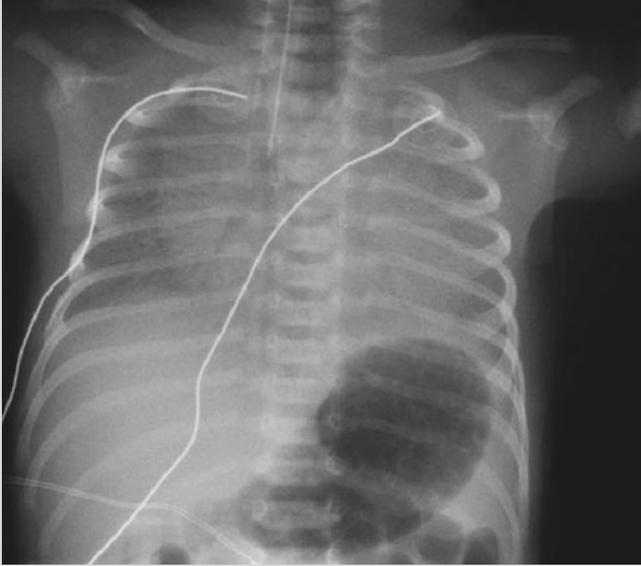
Chest radiograph 1 h after birth showing ground glass appearance, air bronchograms, and decreased lung volume consistent with respiratory distress syndrome (RDS)
